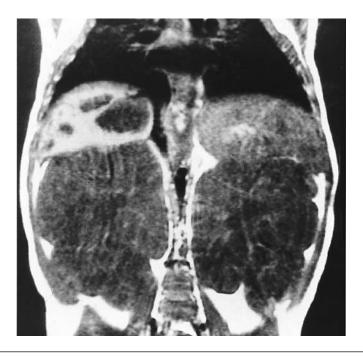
CT appearance of autosomal recessive polycystic kidney disease (ARPKD). Note the presence of dramatically enlarged kidneys and multiple tiny cysts.
